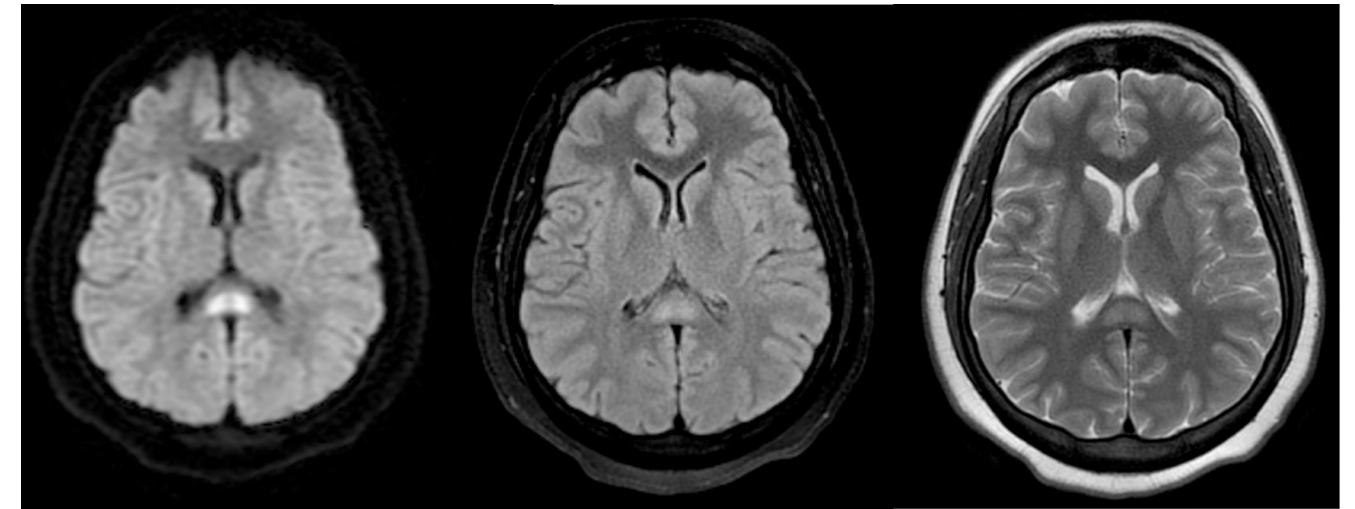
Patient's initial axial MRI brain images (sequences from left to right are DWI, FLAIR, T2). CLOCCs can be visualized posterior midline.
